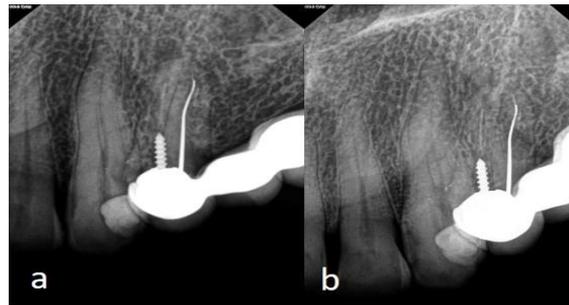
Preoperative radiographic view a) bisecting angle technique b) cone shift technique
